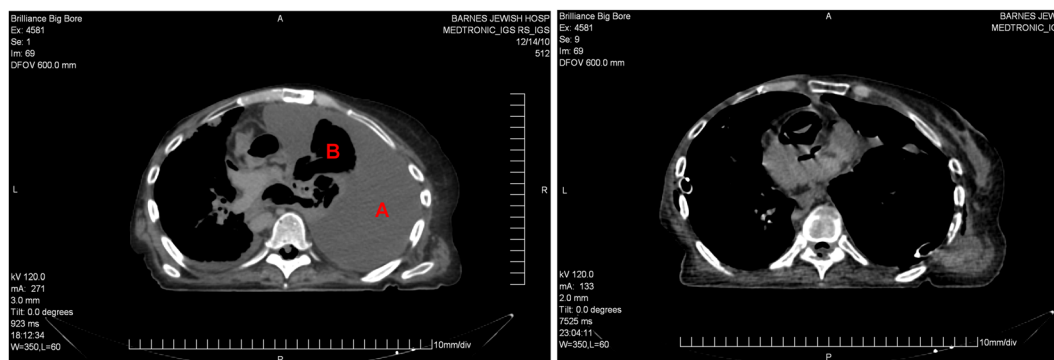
Pleural effusion. Substantial fluid buildup (A) was present in one lung prior to draining via a chest tube affixed to a vacuum source. The lung was collapsed (B) prior to draining and this might have reduced the amount of respiratory related target motion for the two targets implanted into this lung. The right is a CT of the same lung after draining the fluid
